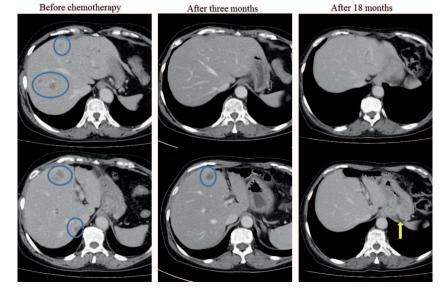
CT scan findings in a 68-year-old woman with gastric cancer and liver metastases. Multiple liver metastases showed a complete response with administration of T-mab-containing chemotherapy. However, the primary tumor developed resistance to therapy and recurred with progressive growth (arrowhead).
